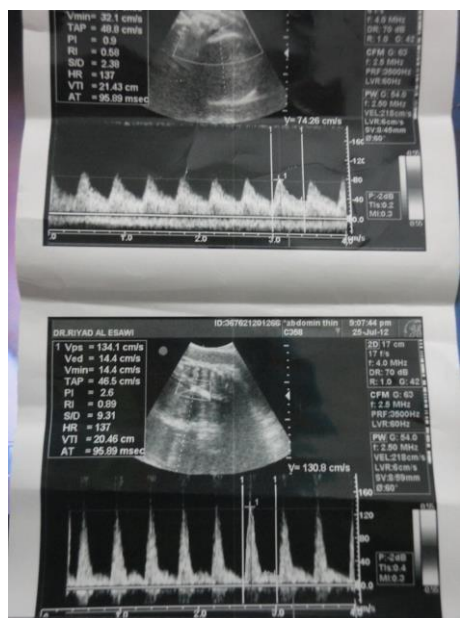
Doppler wave forms of AU (above) & Ao (below) at 40 weeks of gestation).
